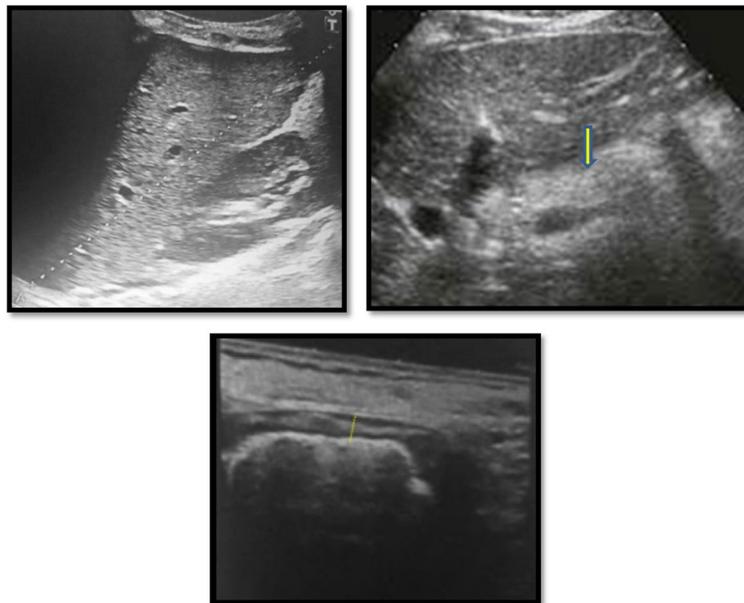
A child known to have cystic fibrosis. She was complaining of chronic cough, recurrent abdominal pain, failure to thrive, and steatorrhea improving on pancreatic enzyme replacement therapy. Her labs are as follows: ALT, 19; AST, 25; Na, 138; K, 3.6; and random blood glucose, 130. Ultrasound of the abdomen shows heterogeneous liver parenchyma with hepatomegaly measuring about 14.7 cm, increased pancreatic echogenicity (pancreatic lipomatosis, arrow), and increased small bowel wall thickening measuring up to 0.5 cm
